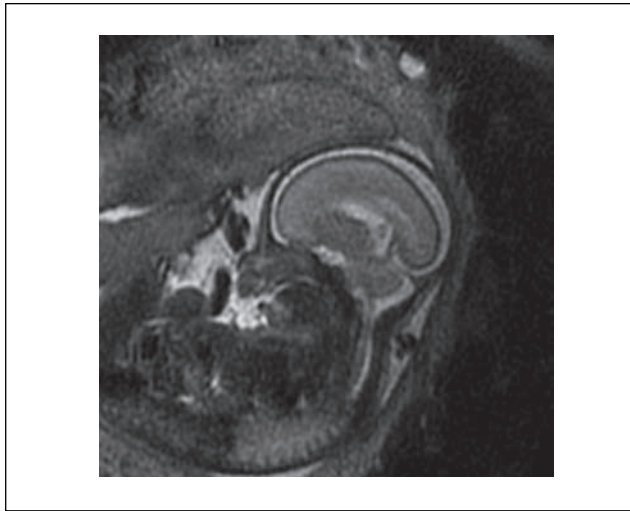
Fetus, 25 weeks GA, case no 13. MRI, SSFSE sequence, T2WI, sagittal plane. Premaxillary protrusion resulting from the elevation of the median nasal prominence in the bilateral cleft.
